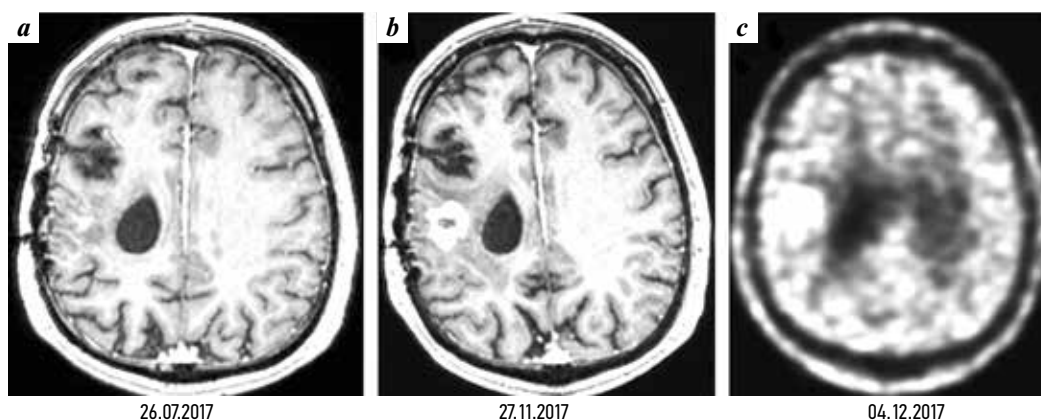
A series of control MRI scans of patient H. with an intracerebral tumor of the right frontoparietal region with a cystic component: a, b – MRI, T1 mode with contrast, axial scan; c – PET of the brain with methionine, axial scan. Local continued growth of glioblastoma with spread downwards from the residual formation is noted
